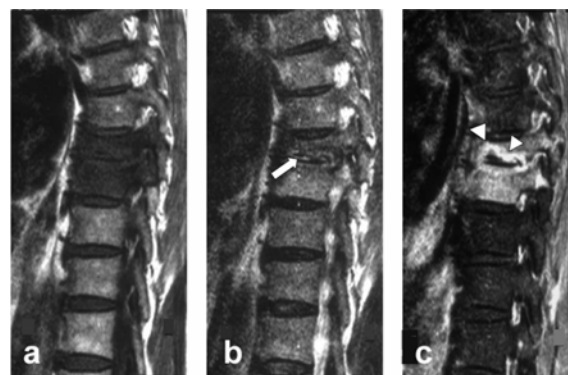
Tuberculosis spondylitis of T8-9, (a, b, c) Magnetic resonance image of the thoracic spine in a 58-year-old woman presented with back pain, (a) Pre-Gadolinium T1-Weighted in sagittal plane (b) T2-weighted in sagittal plane (c) post-Gadolinium T1-Weighted in sagittal plane show typical pattern of two vertebral bodies destruction with intervening disc involvement, linear high signal intensity of disc on T2-weighted images is well appreciated (white arrow), after Gadolinium enhancement, there is enhancement of the involved vertebra including posterior element, irregular rim enhancing intervertebral disc is present (white arrow heads), collapse of T8 vertebra is noted
